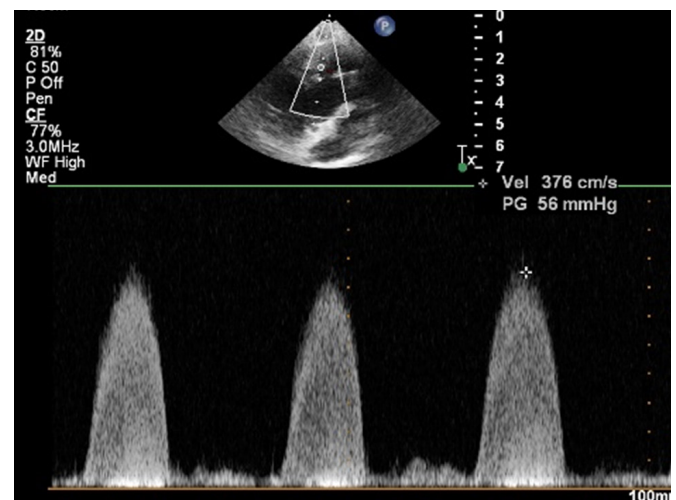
Peak gradient over bulboventricular septal defect (VSD) was around 50 mmHg, measured by echocardiography.
